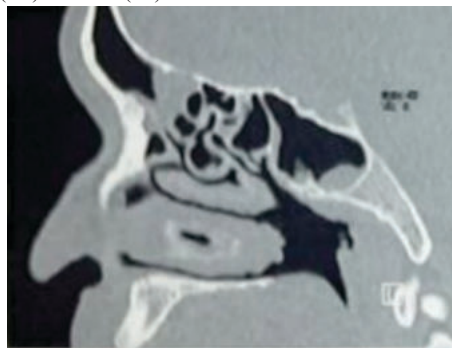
CT Scan Showing Obliteration of Frontal Sinus Drainage Pathway : Supra-bullar Cells
